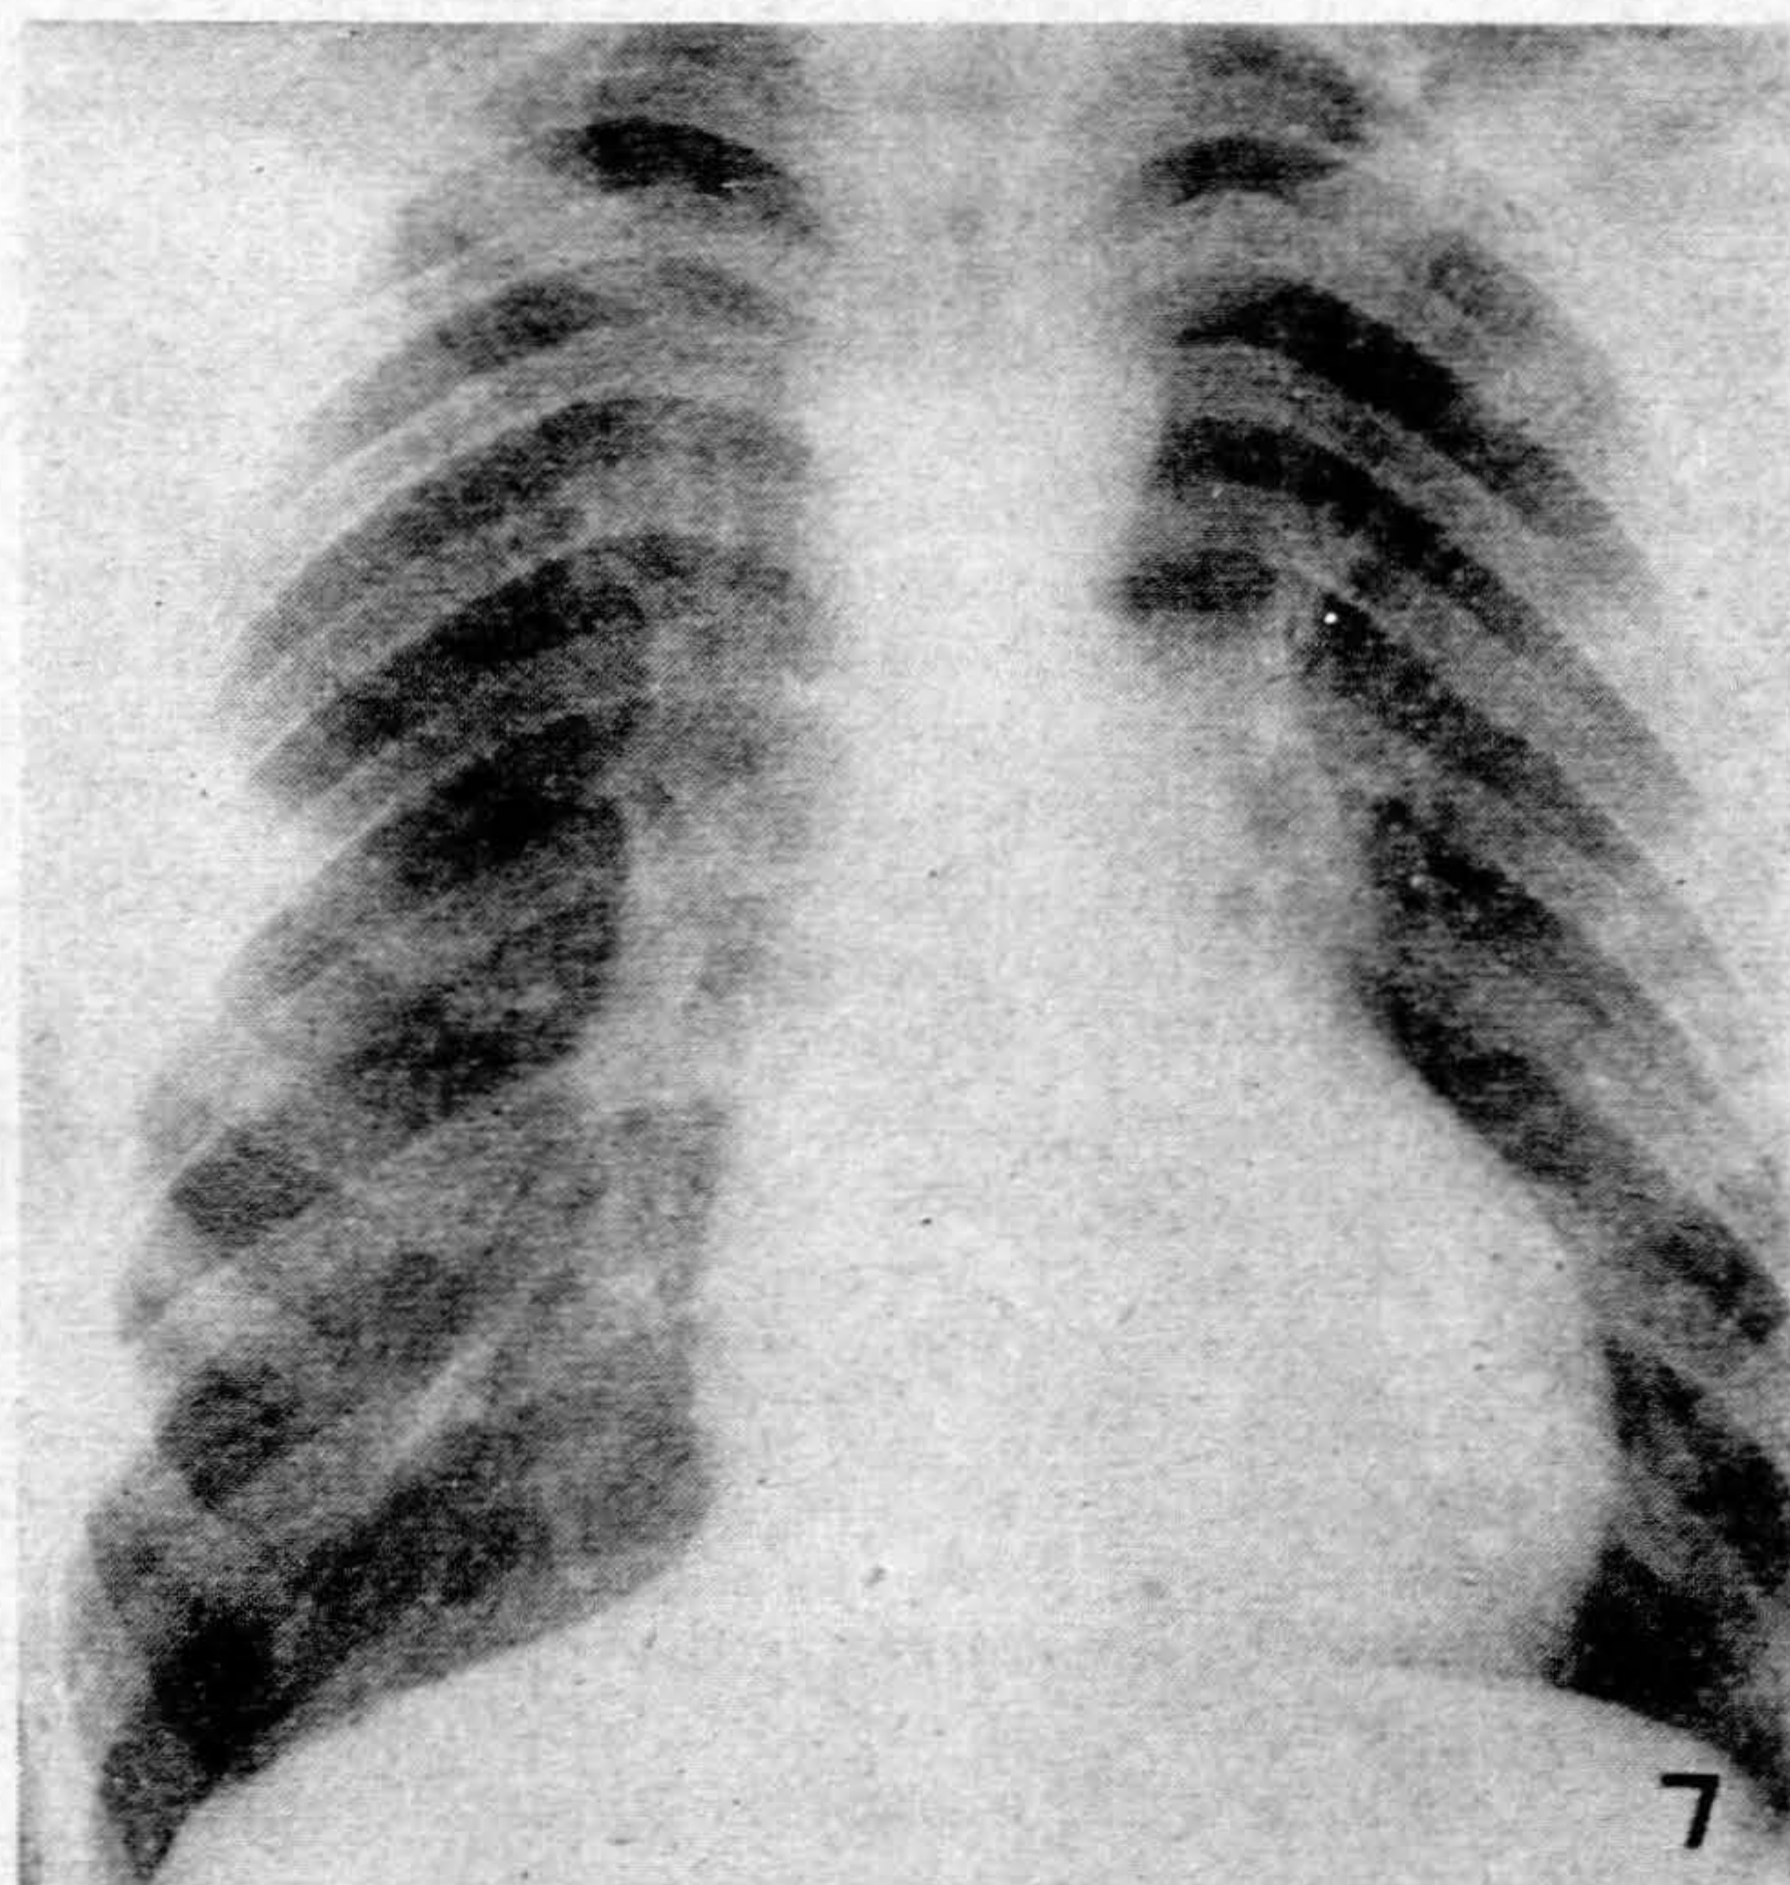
Radiograph showing right ventricular enlargement, prominent pulmonary arteries and high aortic arch.
